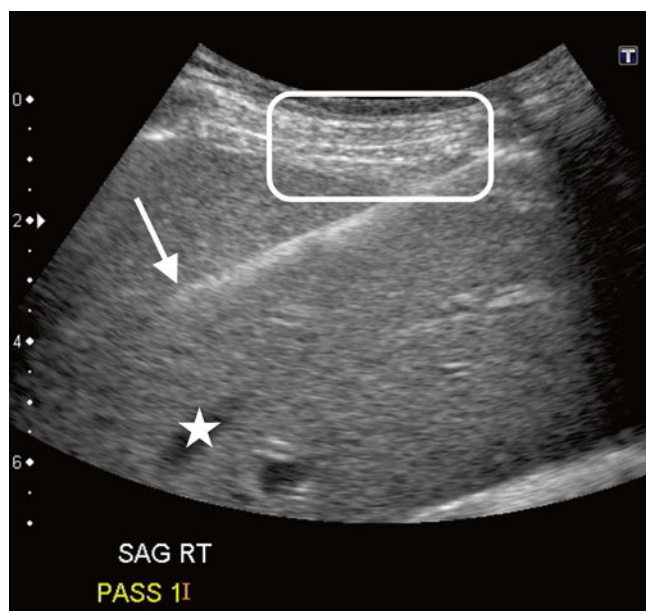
Ultrasound-guided liver biopsy. The image shows a bright echogenic needle being guided under a curved array ultrasound transducer for a random liver biopsy. The needle tip is denoted by the white arrow. This was a random liver biopsy. Ultrasound allows the radiologist to visualize the needle tip live during placement to avoid structures such as large blood vessels (*white star*). Ultrasound is useful for liver biopsies because of the proximity of the organ to the skin (the white box denotes the subcutaneous tissues and measures roughly 1–2 cm)
